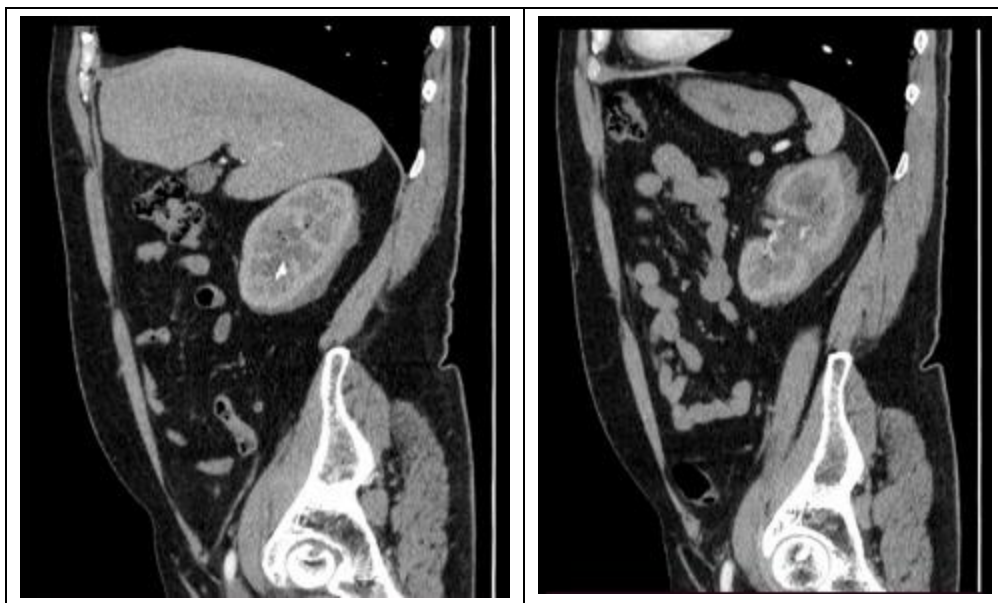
Sagittal CT scan images showed perirenal soft tissue thickening extending to the renal pelvis and infiltrating the pelvicalyceal systems, associated with moderate hydronephrosis, giving the appearance of "hairy kidneys."
